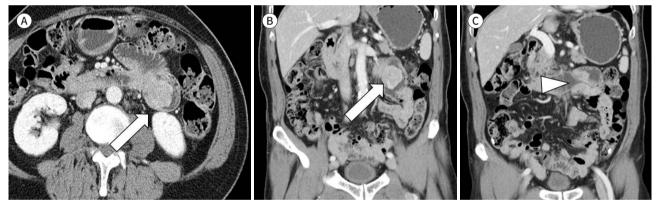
Surgically confirmed GIST in the proximal jejunum in a 71-year-old male while evaluating nonspecific abdominal pain. A-C. Axial (A) and coronal (B, C) contrast-enhanced CT images show a 2 cm sized, well-enhancing, hypervascular mass (arrows) in the proximal jejunum, with jejuno-jejunal intussusception (arrowhead).
